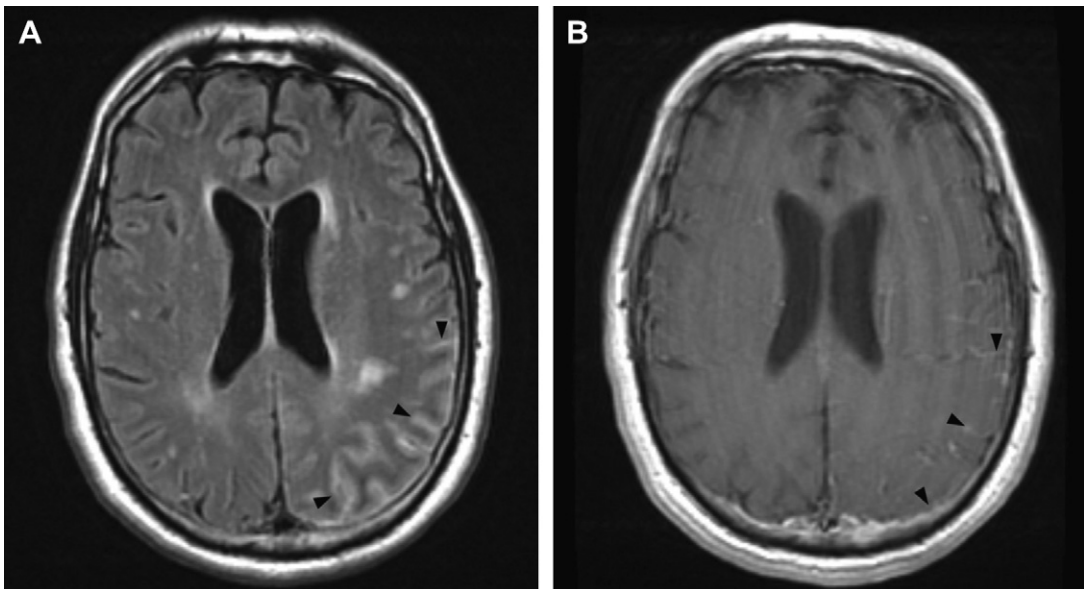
(A) Axial FLAIR image through the brain shows increased signal along the left parietal cerebral sulci (arrowheads) in a patient with meningoencephalitis. (B) Corresponding axial T1WI shows localized pial enhancement along the parietal sulci and overlying meninges (arrowheads).
